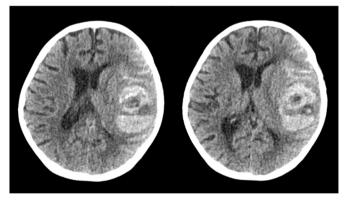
Secondary brain computed tomography of the patient. Spontaneous intracranial hemorrhage in the left parietal lobe occurred in a previously noted left temporal lobe abscess.
